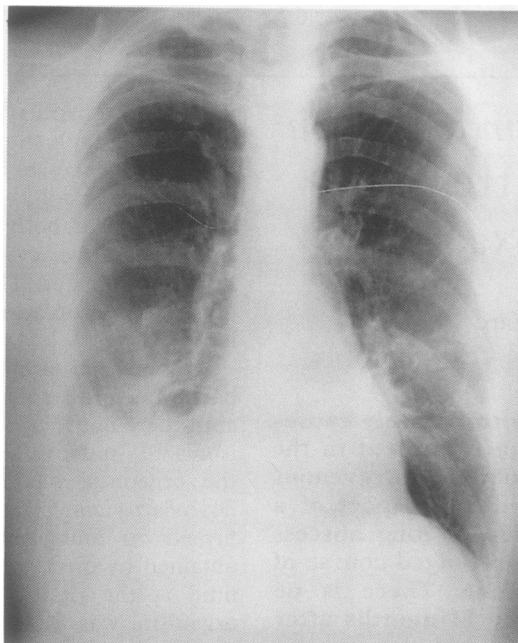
Chest radiograph after nine months' treatment.
